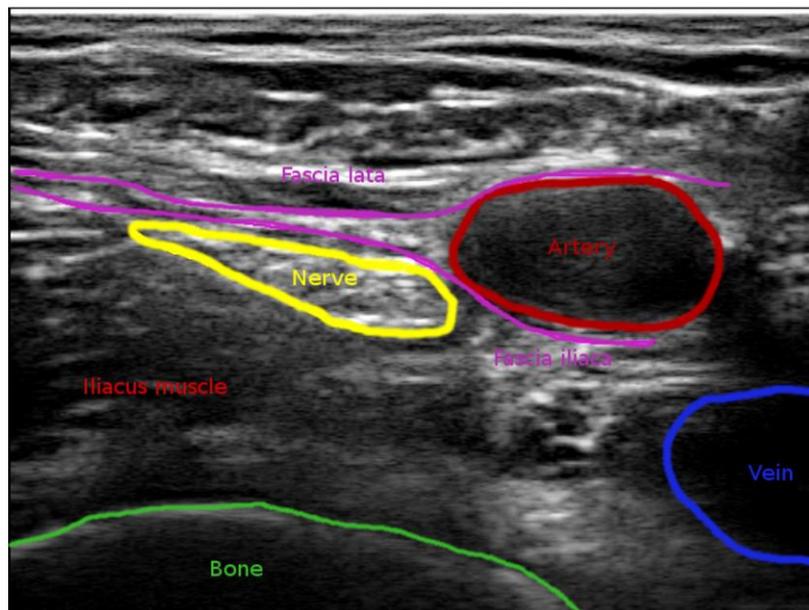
Ultrasound image of the femoral nerve.
